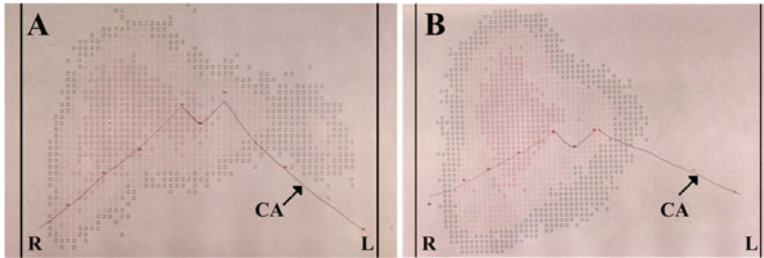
$^{113\text{m}}\text{In}$ colloid liver scintigraphy of normal liver (a) and hepatomegaly (b). Red numbers indicate high, yellow numbers medium and blue numbers low level of radioactivity. University doctoral dissertation. Figs. 21 and 22. Department of Internal Medicine, Medical University, Szeged. *R* right side, *L* left side of the patient, *CA* costal arch. The costal arch is the lower margin of the chest formed by the bottom edge of the rib cage (With permission Banfalvi 1971)
